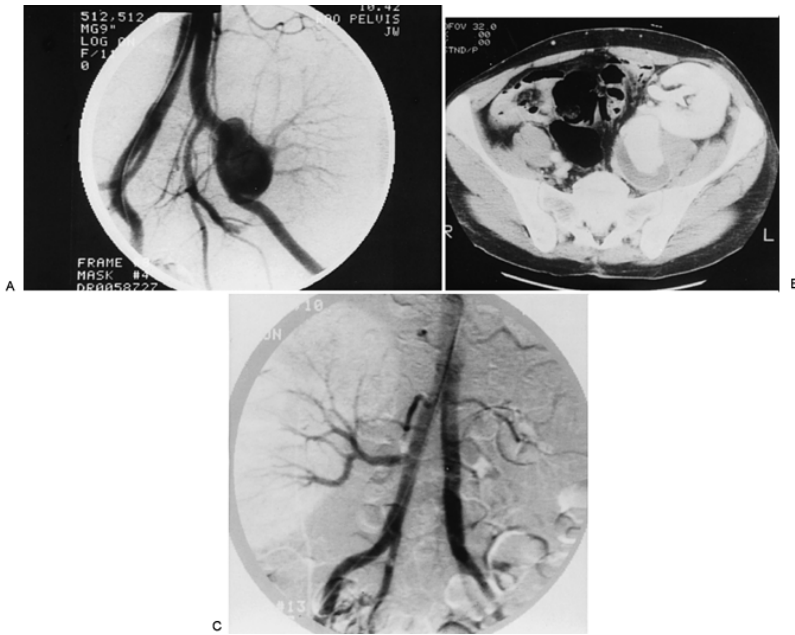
A: Arteriogram reveals large pseudoaneurysm arising near arterial anastomosis between renal artery and left external iliac artery. Intrarenal vasculature can be seen lateral to pseudoaneurysm. B: Pelvic computed tomography scan shows large renal artery pseudoaneurysm extending posteriorly in left iliac fossa. C: Following extracorporeal revascularization and autotransplantation, arteriogram shows patent anastomosis of reconstructed renal artery to right common iliac artery. (From Campbell SC, Gill I, Novick AC. Delayed allograft autotransplantation after excision of a large symptomatic renal artery pseudoaneurysm. *J Urol* 1993;149:361, with permission.)
